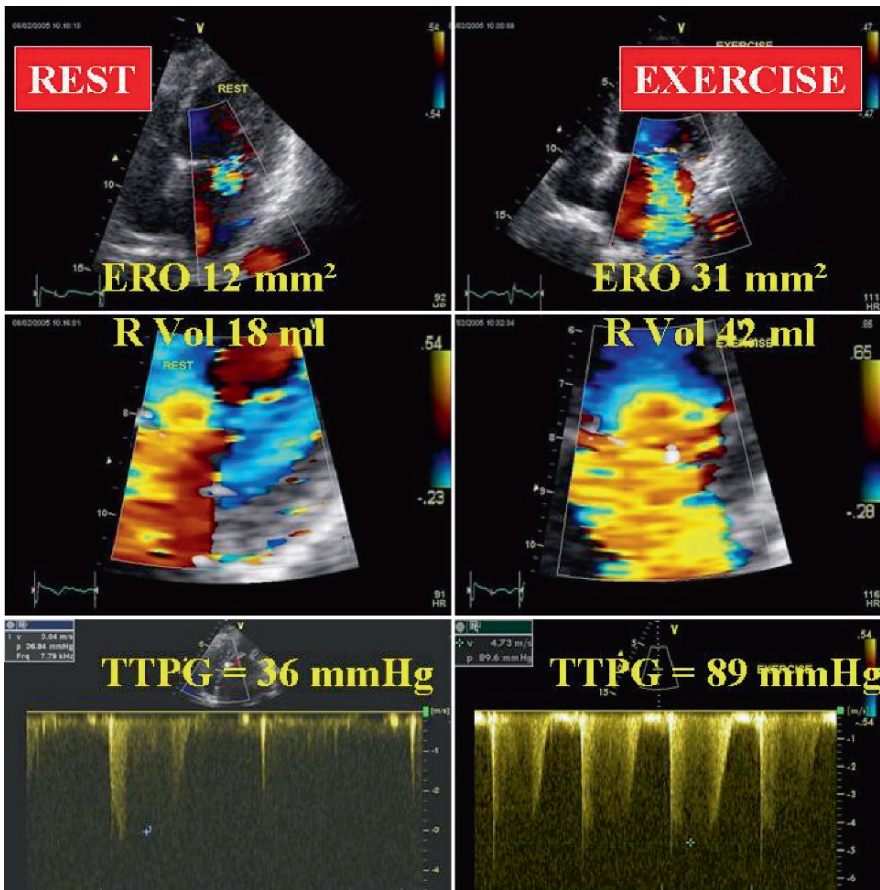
Apical 4-chamber view showing color-flow Doppler and proximal flow-convergence region at rest and during exercise in a patient with a large exercise-induced increase in mitral regurgitation and estimated pulmonary artery systolic pressure. *ERO*, effective regurgitant orifice; *RVol*, regurgitant volume; *TTPG*, systolic transtricuspid pressure gradient
